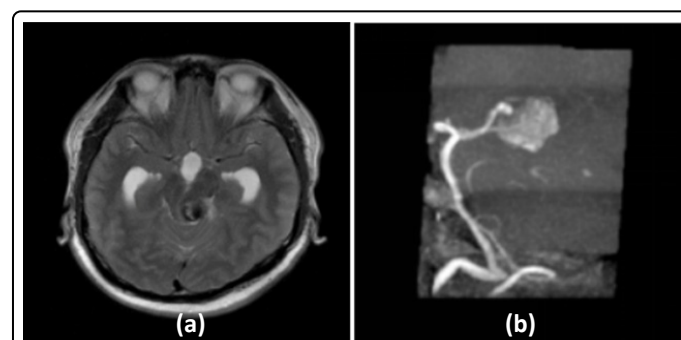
a): MRI T2 weighted axial sections of Brain shows partially thrombosed aneurysm arising from the left posterior cerebral artery causing compression effect over the ventricular system resulting in moderate hydrocephalus and CSF seepage; b): MRA which shows an aneurysm arising from the left posterior cerebral artery.
